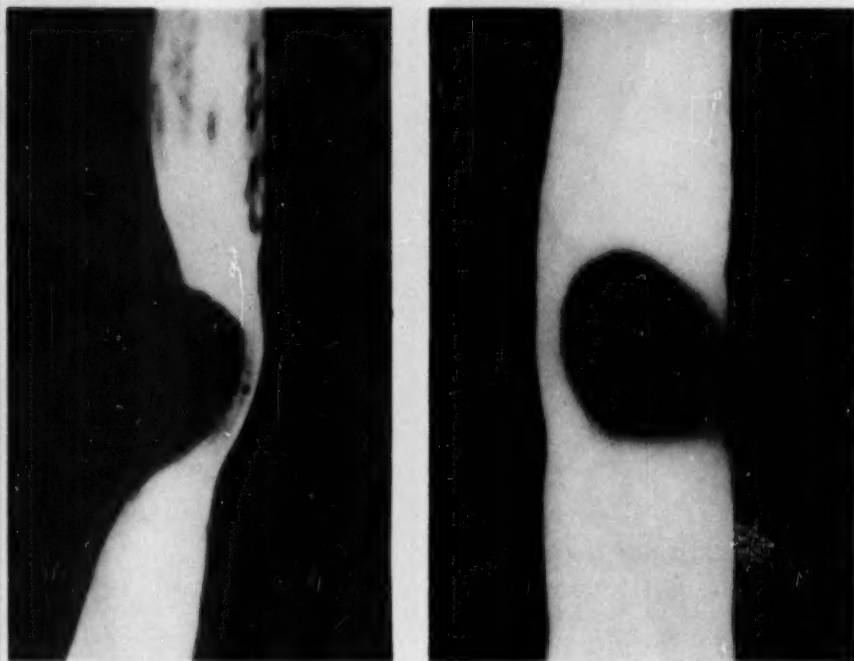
Artificially produced extrinsic tumor which is attached to the esophageal wall in its upper pole. (A piece of cork pressed against the esophageal wall and sewed onto it with its upper pole.) Note the sharp upper edge of the lesion in profile and face on view compared with the unattached gradually sloping lower edge in both views. (From Schatzki, R. and Hawes, L. E. *Am. J. Roentgenol.* 48:1-15, 1942.)
